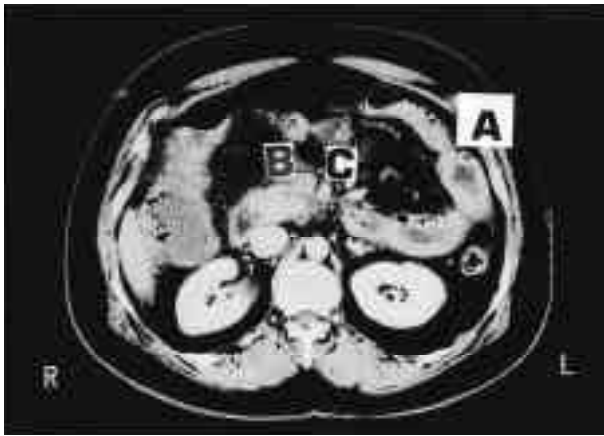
CT scan showing (a) Thickened wall with free gases in small bowel, (b) Filling defect in SMV, (c) Superior mesenteric artery
